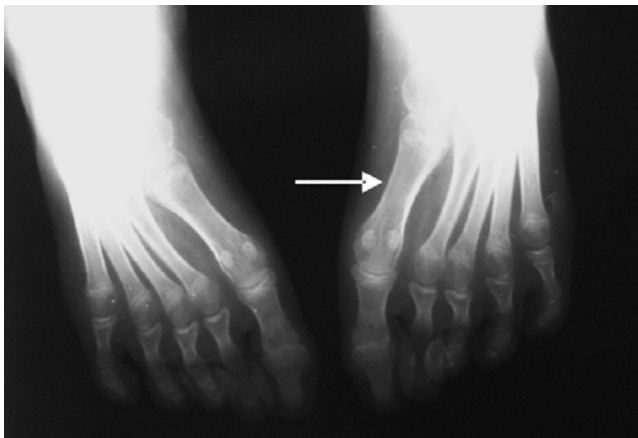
X-ray metatarsus adductus (varus) deformity in both feet
